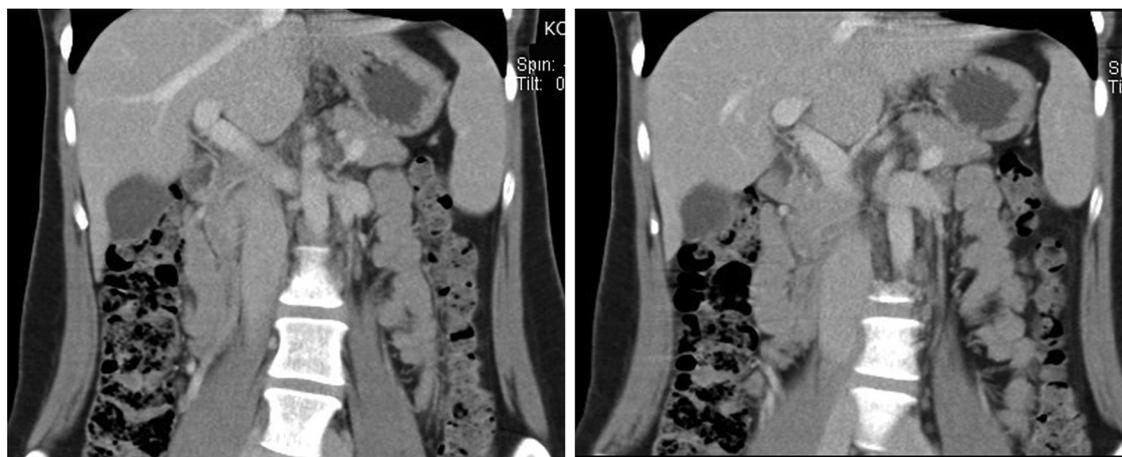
Angio-CT scan of the abdominal cavity 6 months later demonstrated normal and unobstructed superior mesenteric and portal veins with no presence of thrombi.
